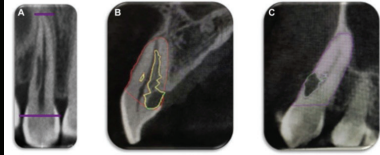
Representative reference points and ECR tracing used for the calculation of lesion volume in Amira. (A) The radiographic apex and 2 mm above the cementoenamel junction were used as reference points for the root. The root, based on (A) reference points, was traced followed by tracing the ECR lesion in both (B) sagittal and (C) coronal slices. The percent of the root affected by ECR was calculated by dividing the ECR volume by the total volume of the root.
